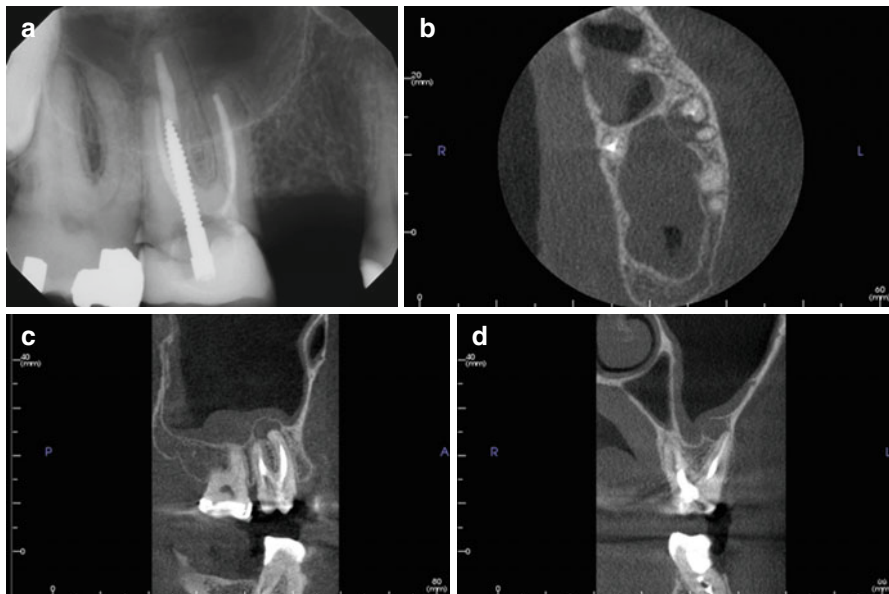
A 49-year-old male was referred for evaluation of tooth number 3 prior to fabrication of a new crown. The root canal treatment was completed approximately 15 years ago and the tooth is currently asymptomatic, periodontal probing depths are WNL, and the tooth is negative to percussion, palpation, and bite stress testing. The referring dentist wants to know if this tooth should have treatment revision or surgery prior to a new crown. The periapical radiograph (a) shows possible widening of the apical PDL on all three roots but the extent, or even definitive presence, of apical pathosis is uncertain. CBCT (b, c, and d) reveals a distinct 5.0×8.0-mm periapical lesion with elevation of the sinus floor and inflammatory sinus mucositis (b axial view; c sagittal view; d coronal view)
